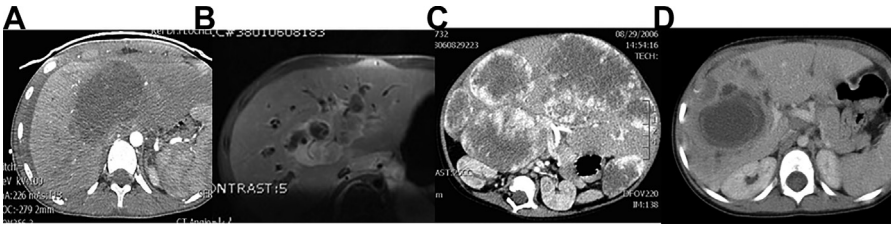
Radiographic appearance of pediatric liver tumors. (A) Undifferentiated embryonal sarcoma (UESL) with a mixture of cystic/myxoid and solid components. (B) Biliary rhabdomyosarcoma, presentation with biliary tract obstruction is common. (C) Multifocal or diffuse subtype of infantile hepatic hemangioma can involve the entire liver with significant hepatomegaly. (D) Mesenchymal hamartoma presents as a multicystic mass with thick vascular septatae.
